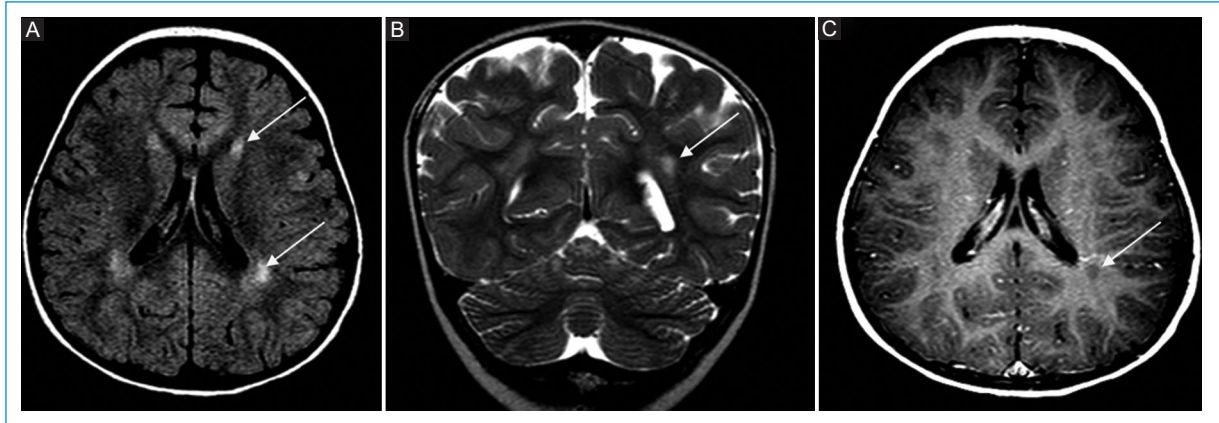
A: T2 FLAIR brain MRI axial image revealing hyperintense lesions in the posterior corona radiata and bilateral frontal periventricular substance. B: T2 coronal brain MRI revealing hyperintense lesions in the corona radiata; C: T1 axial brain MRI with contrast revealing hypointense lesions with no contrast uptake.
